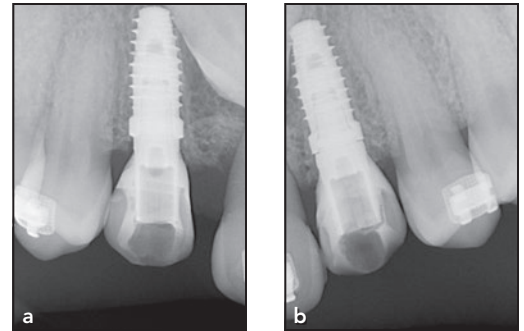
Case 1. Periapical radiographs of the (a) left and (b) right sides taken immediately after implant insertion (baseline).
